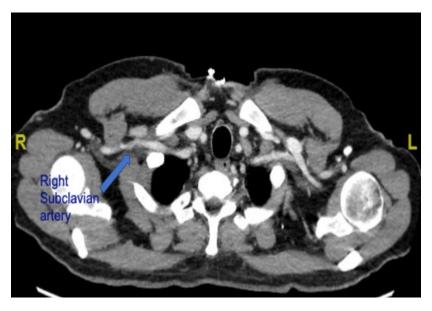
Postoperative computed tomography scan of the chest revealed no stenosis or filling defect in the right SCA (blue arrow).
